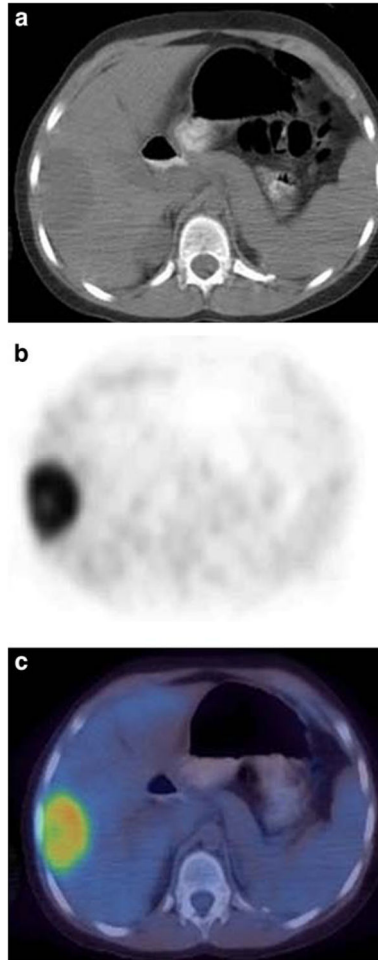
Patient 27: 8-year-old girl with recurrent Wilms' tumor showing focal uptake in the liver consistent with metastatic disease. a Noncontrast transverse CT image of the abdomen. b FDG PET at same level as a. c Fusion image of a and b
